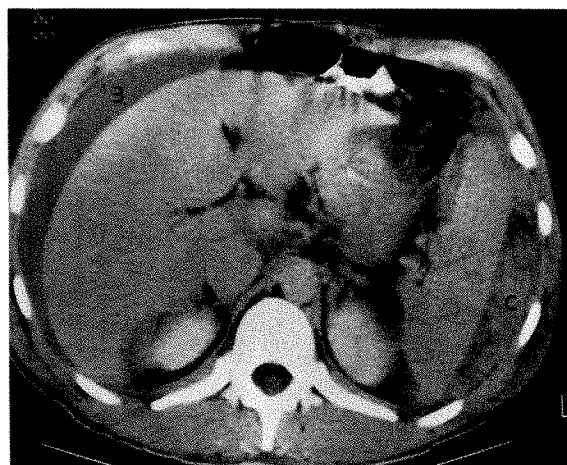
Surgically confirmed splenic injury with perisplenic hematomas. CT scan shows hyperdense clot (C) relative to lower density of lysed blood (B) surrounding liver.
